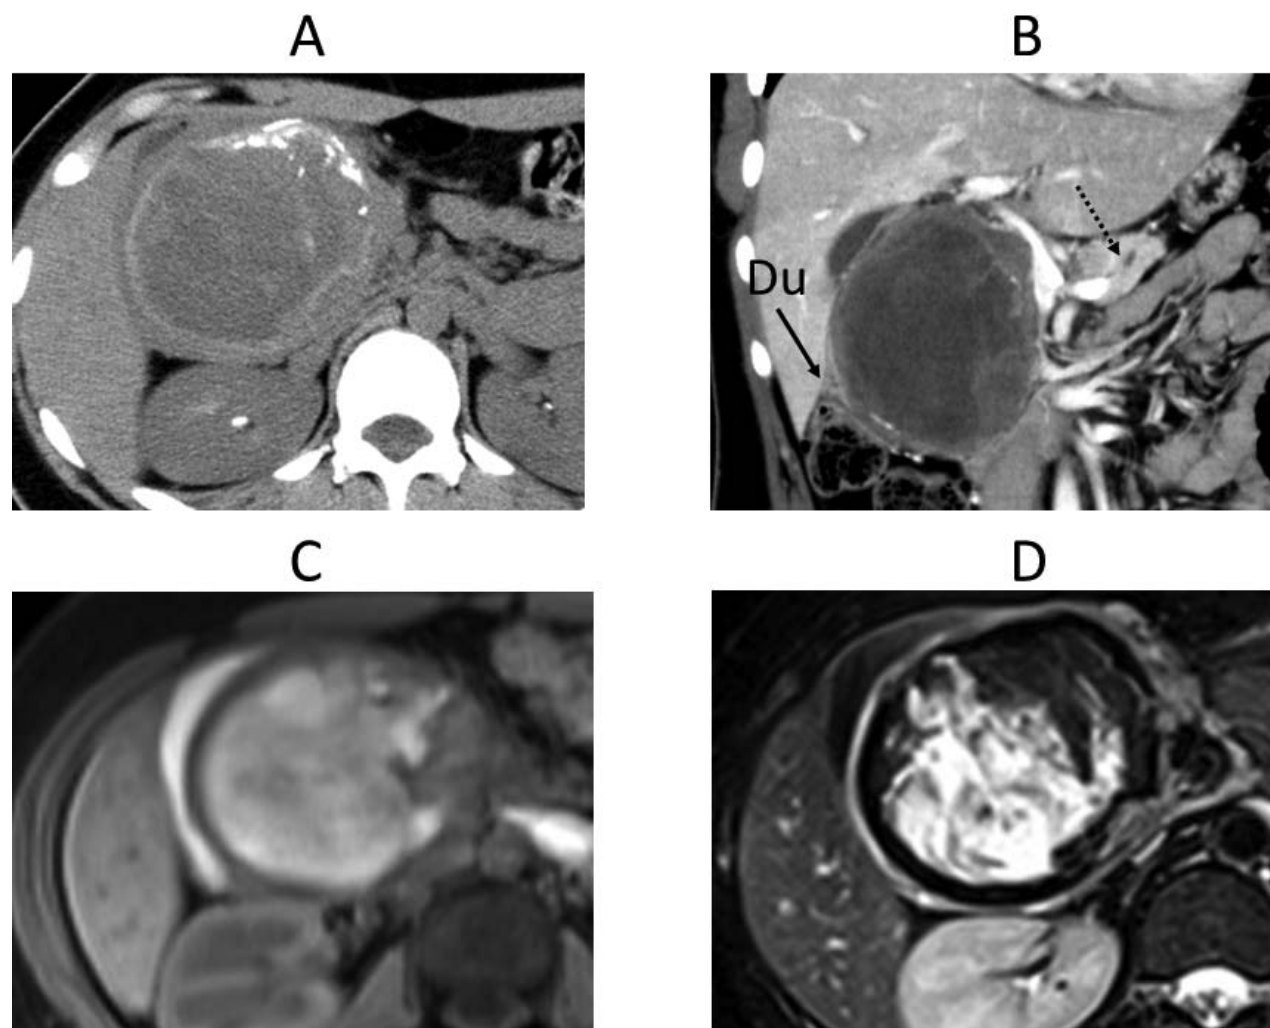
(A) Nonenhanced CT examined at a previous hospital showed a well-defined heterogeneous 8-cm mass with calcification in the pancreatic head. (B) The duodenum (arrow) and portal vein were distorted by the tumor. Dilatation of the main pancreatic duct (dotted arrow) was also revealed by contrasted CT. (C, D) MRI revealed a mass encapsulated with fibrous membrane containing a solid part and various intensities of hemorrhage. (C) T1-weighted image. (D) T2-weighted image.
